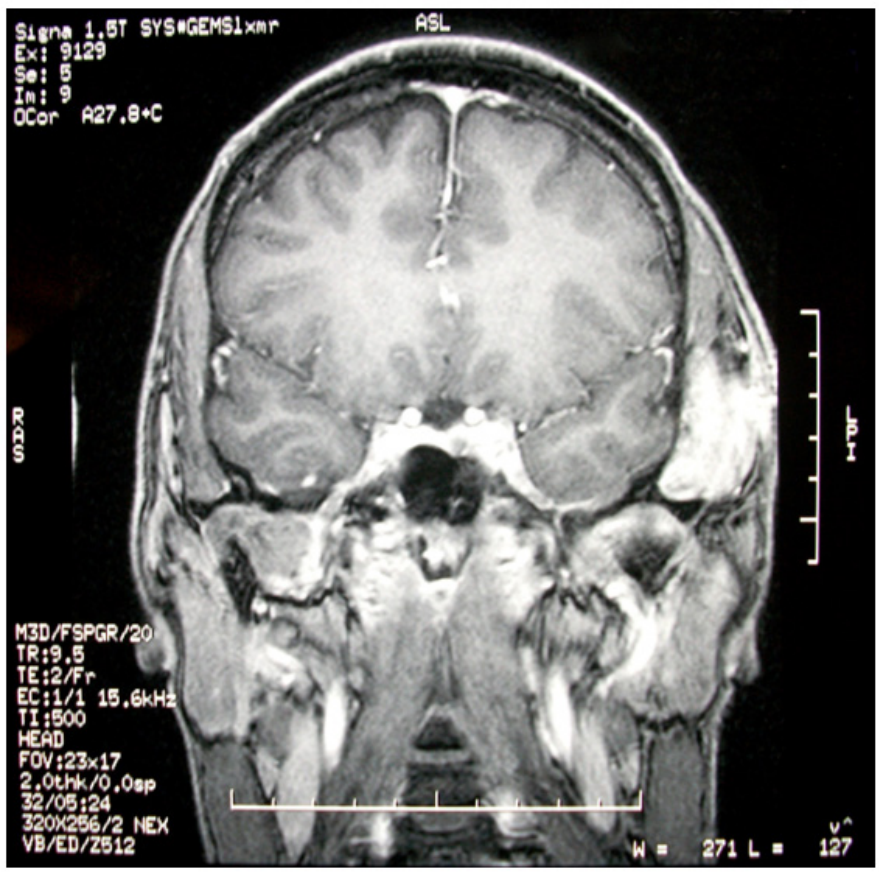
Magnetic resonance image showing a soft tissue lesion in the left temporalis area.
